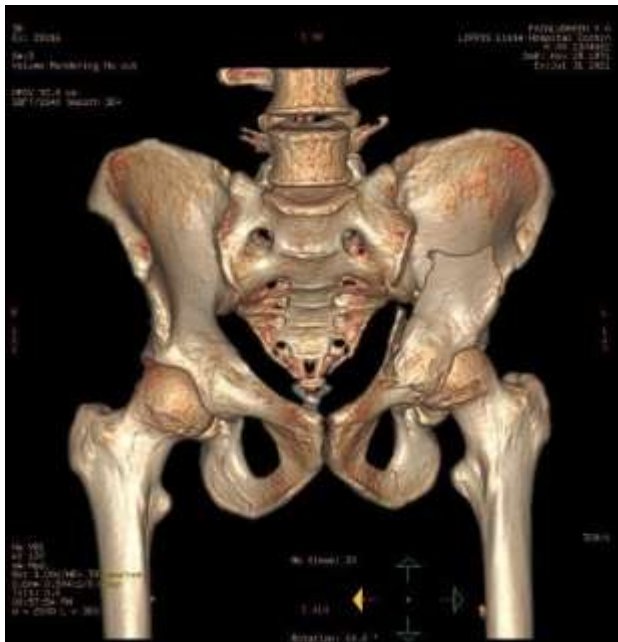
3d CT reconstruction of pelvis showing fracture
